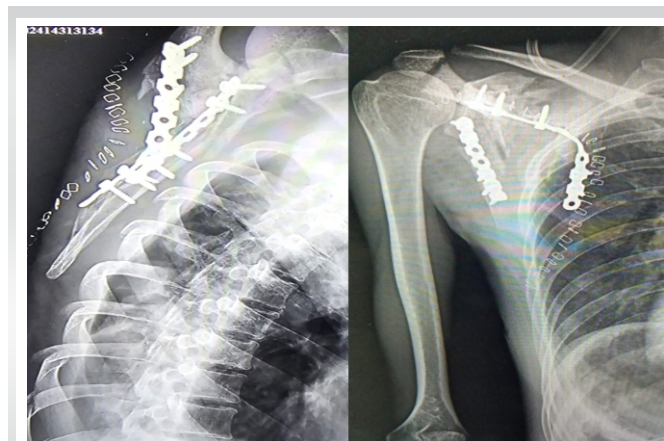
Immediate post-operative anteroposterior (right) and scapular Y-view (left) radiographs of the left shoulder following the first surgical procedure; the images show dual-column reconstruction of the scapula with plate fixation of both the medial and lateral columns. Restoration of scapular alignment and structural integrity is evident, reflecting the initial phase of surgical stabilization in the management of complex scapulothoracic disruption.
